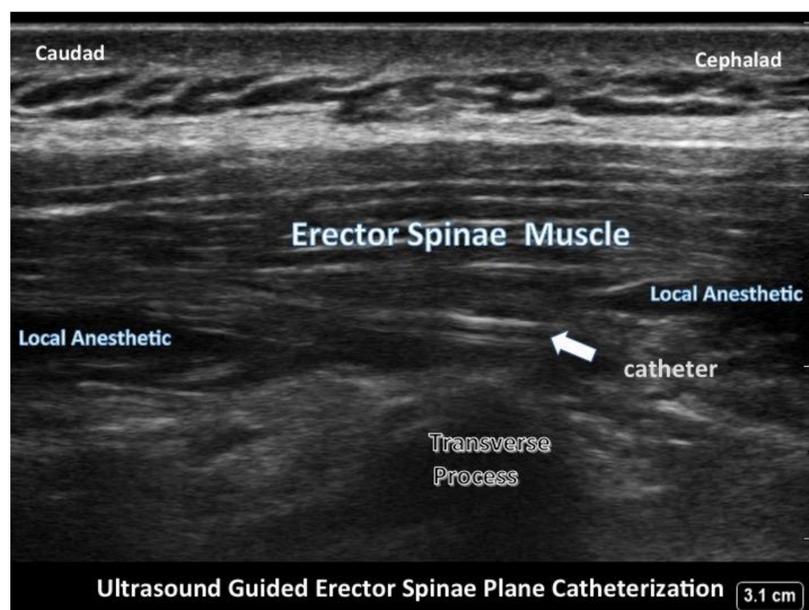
Ultrasound Image of Right Sided Erector Spinae Plane Block with Spread after Local Anesthetic Injection
